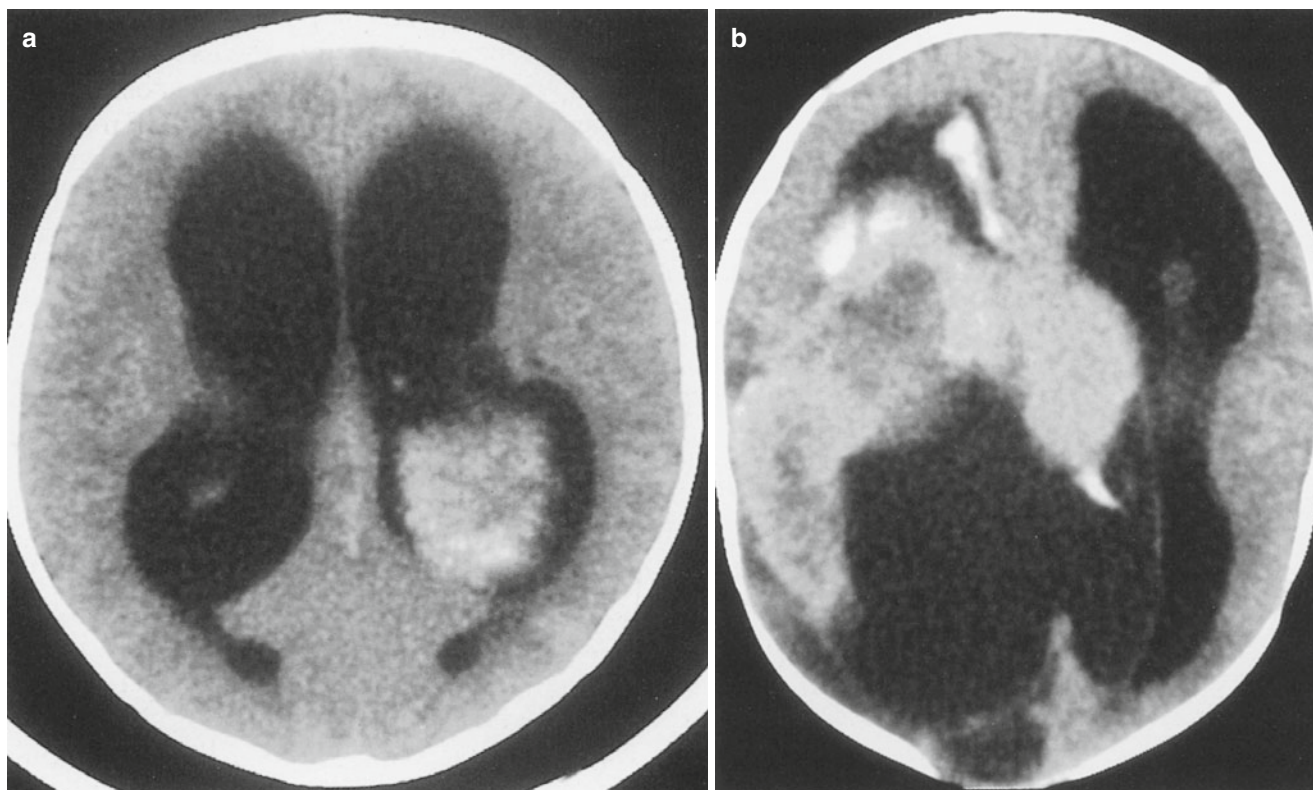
(a) CT scan showing benign choroid plexus papilloma. (b) CT scan showing choroid plexus carcinoma
